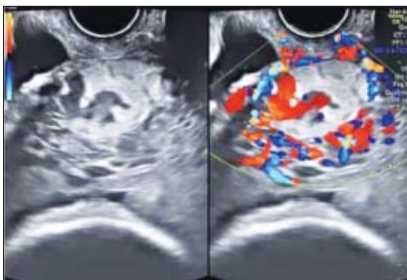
Color doppler USG showing multiple vascular lacunae
